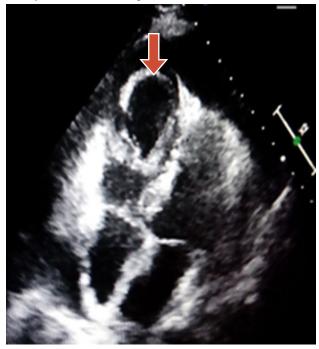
Transthoracic Echocardiography showing a mass at right ventricular apex
